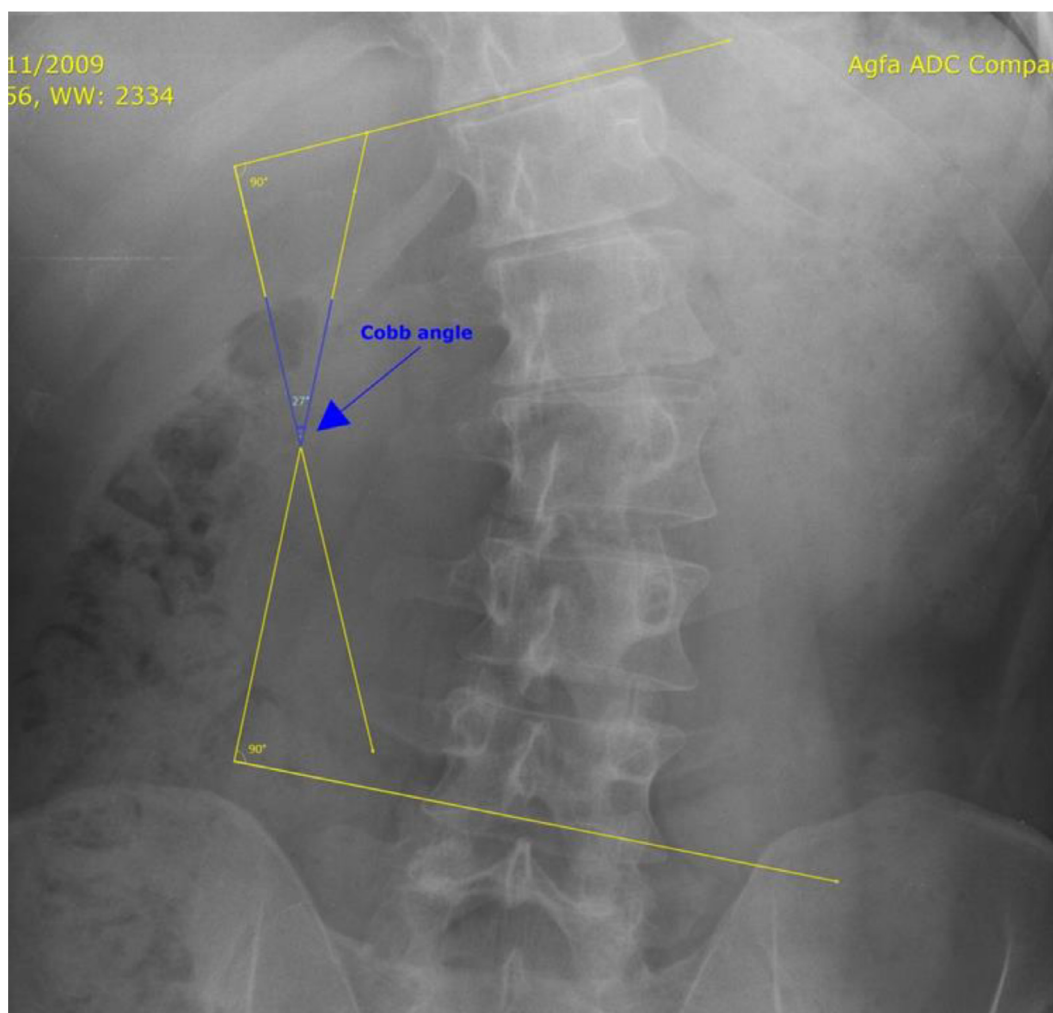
Cobb's angle measurement on an anteroposterior radiograph of the lumbar spine.
